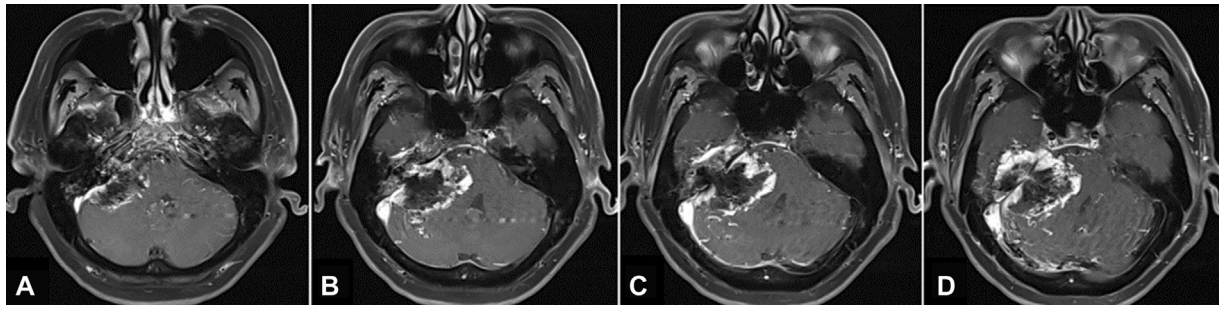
(A–D) Sequential axial T1-weighted gadolinium-enhanced magnetic resonance images of the brain, obtained 4 days after embolization, demonstrate significant devascularization of the tumor.
